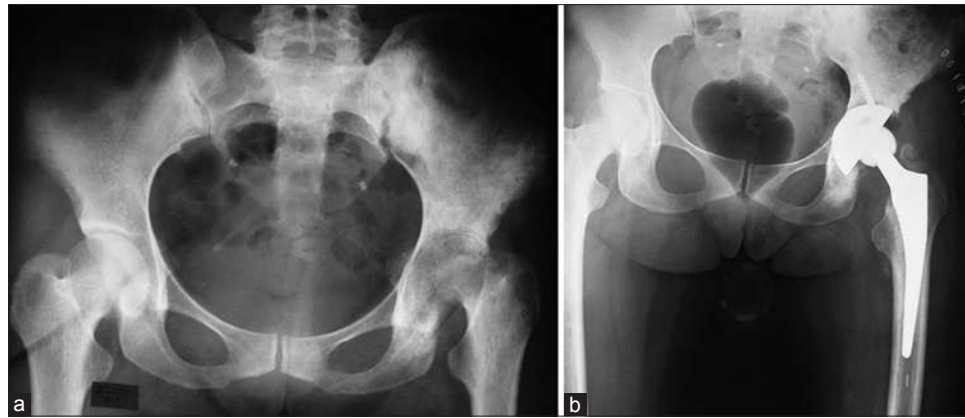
X-ray pelvis with both hip joints anteroposterior view showing (a) tubercular arthritis of left hip. (b) After uncemented total hip arthroplasty (with permission from A K Rai, BHU)
